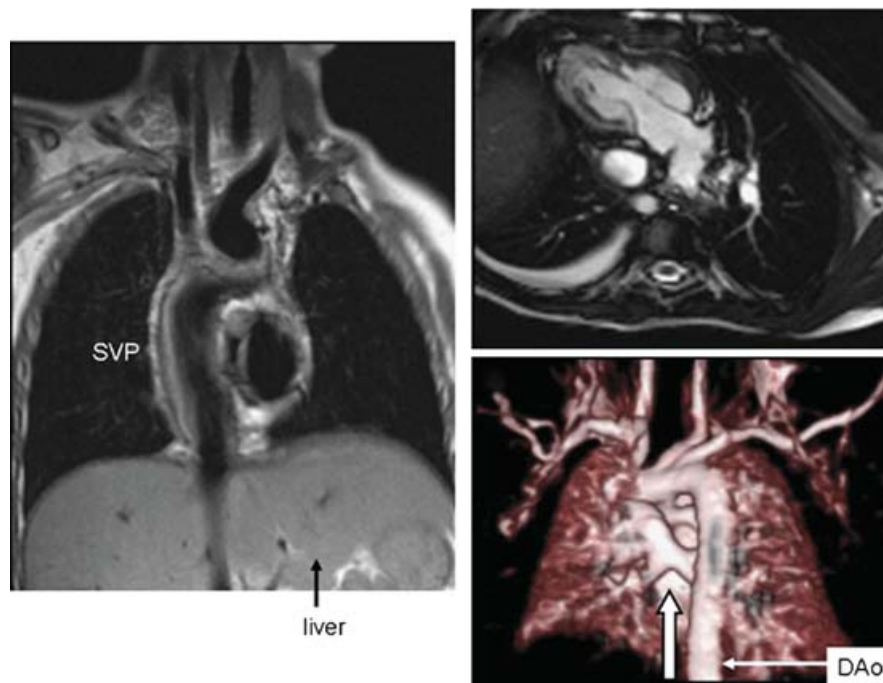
Examples of the use of magnetic resonance imaging in the setting of heterotaxy. The image on the left is a double inversion dark blood image of a patient with a functionally single ventricle after conversion to the Fontan circulation. Note the midline liver and the systemic venous pathway (SVP). The upper right panel is an example of steady state free precession bright blood imaging of a "2-chamber view" of another patient with a functionally single ventricle who has a right-sided heart with the apex pointing to the right. The patient also has a small right pleural effusion. The lower right panel is a three-dimensional reconstruction utilizing gadolinium viewed posteriorly of a patient with totally anomalous venous connection to the superior caval vein. Note the ascending vertical vein (arrow) receiving all four pulmonary veins. DAo = descending aorta.
